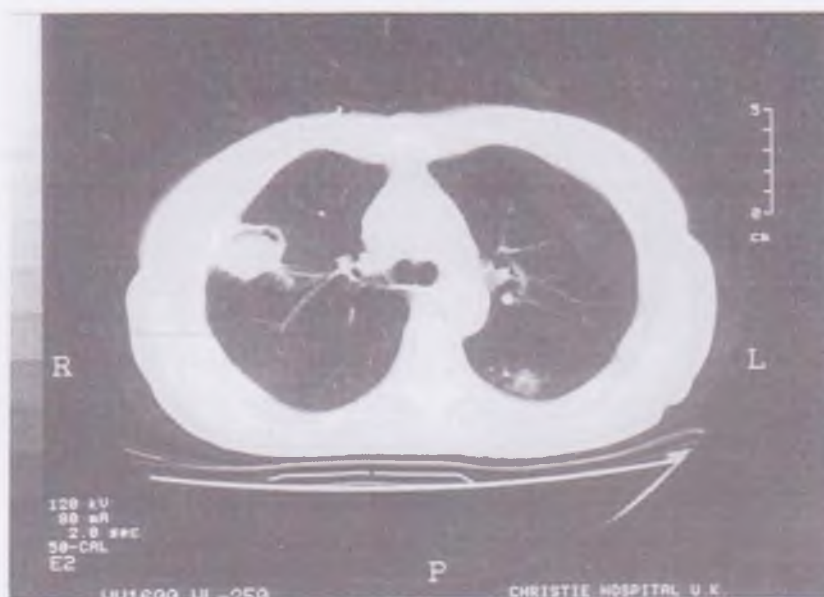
CT scan appearance of a neutropenic leukemic patient showing two lesions. The one on the right side exhibits the characteristic "air crescent" sign. It is a pleural-based lesion with at least two sharp borders, both features typical of invasive pulmonary aspergillosis. The other smaller lesion on the left posteriorly demonstrates the "halo sign".
